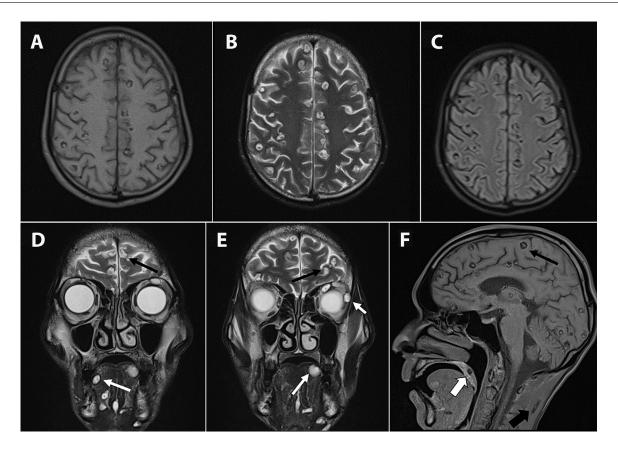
Magnetic resonance images of the brain: (A) T1 weighted axial image showing multiple iso intense lesions with central high signal intensity scolex in bilateral cerebral hemispheres. (B and C) T2 weighted and FLAIR axial images showing T2 high signal intensity cysts suppressed on FLAIR images with central scolex in bilateral cerebral hemispheres. (D and E) T2 weighted coronal images of the brain showing cysts in bilateral cerebral hemispheres (black arrows), tongue (long white arrows) and extra-ocular muscles (short white arrow). (F) T1 weighted sagittal image showing cysts in cerebral hemispheres (black arrows), soft palate (white boxed arrow) and trapezius muscle (black boxed arrow).
